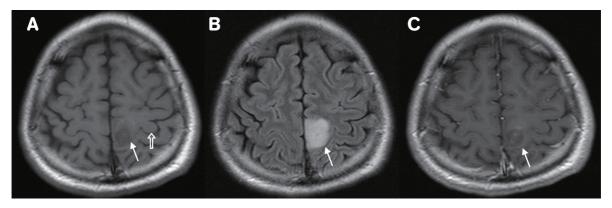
(A) T1-weighted image showed a low signal lesion (arrow) medial to the hand knob area (empty arrow). (B) The lesion turned to high signal in T2-weighted image. (C) It showed faint enhancement after contrast.
